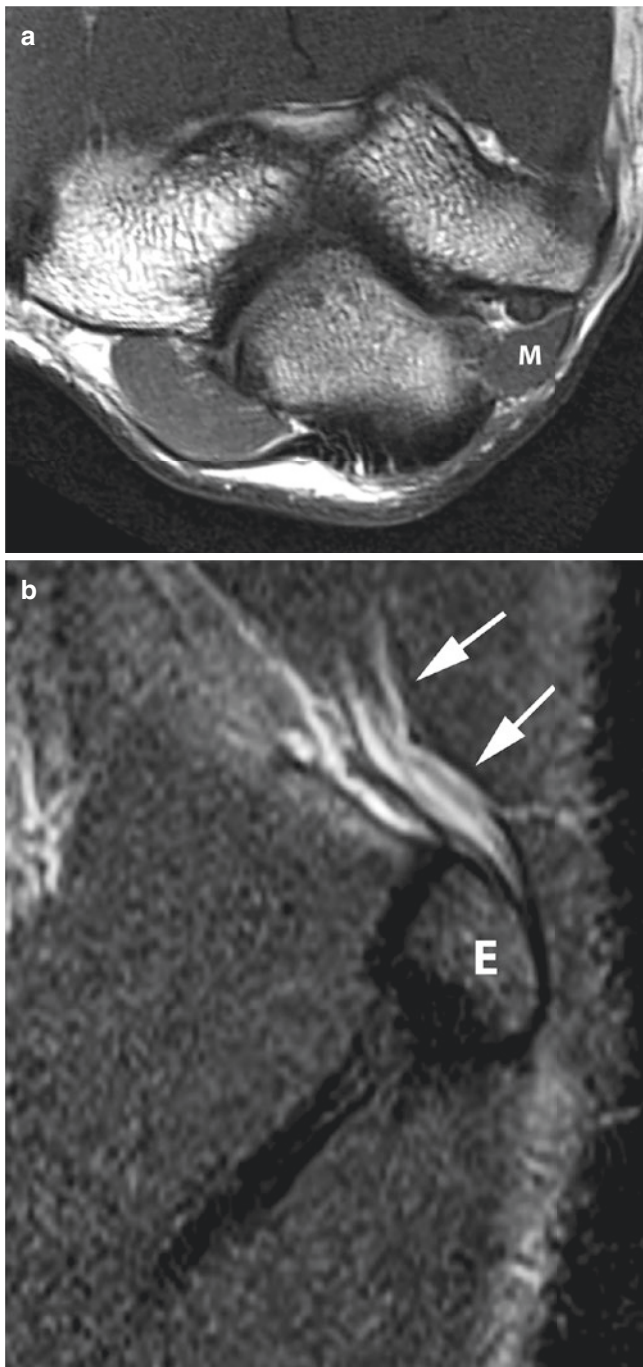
Ulnar neuritis. A 31-year-old male with elbow pain and symptoms of ulnar neuropathy. (a) Axial T1-weighted image reveals an anconeus epitrochlearis muscle (M) superficial to the ulnar nerve within the cubital tunnel. (b) Sagittal STIR image shows an increased signal intensity within a markedly enlarged ulnar nerve just proximal to the cubital tunnel (arrows) (E = medial epicondyle)
